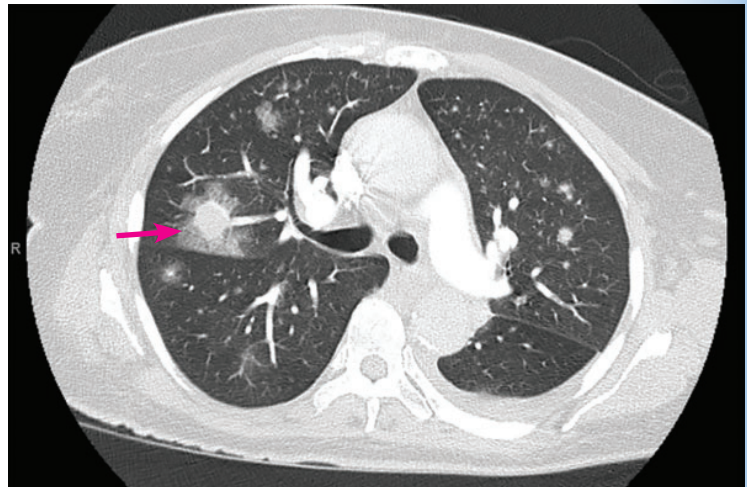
Computed tomography shows multiple pulmonary nodules, some surrounded by ground-glass changes consistent with the “halo” sign (arrow) in a patient with invasive pulmonary aspergillosis.
